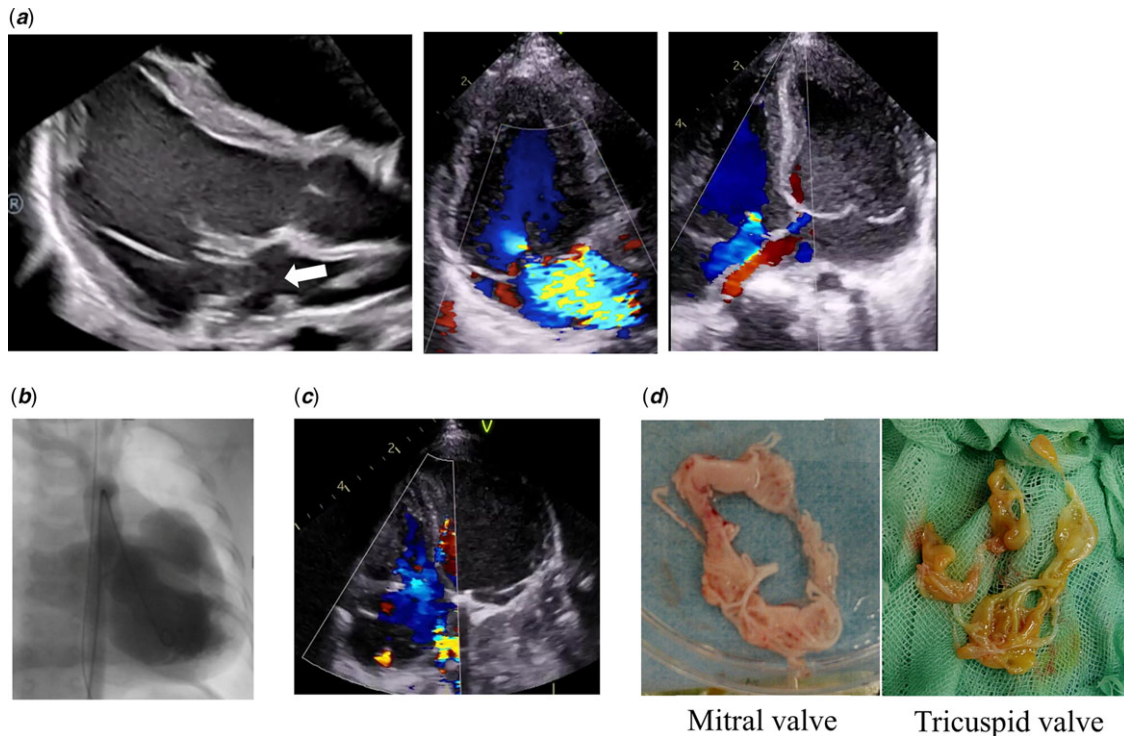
(a) Echocardiographic images show aortic root dilation, left ventricular dilation, posterior mitral prolapse (white arrow) and regurgitation, and tricuspid prolapse and regurgitation. (b) Cardiac angiography shows Sellers IV degree of mitral valve regurgitation. (c) Severe tricuspid regurgitation after mitral valve replacement. (d) Removed mitral (left) and tricuspid (right) valves after valve replacement. These valves are both slightly thickened, with myxomatous degeneration.
